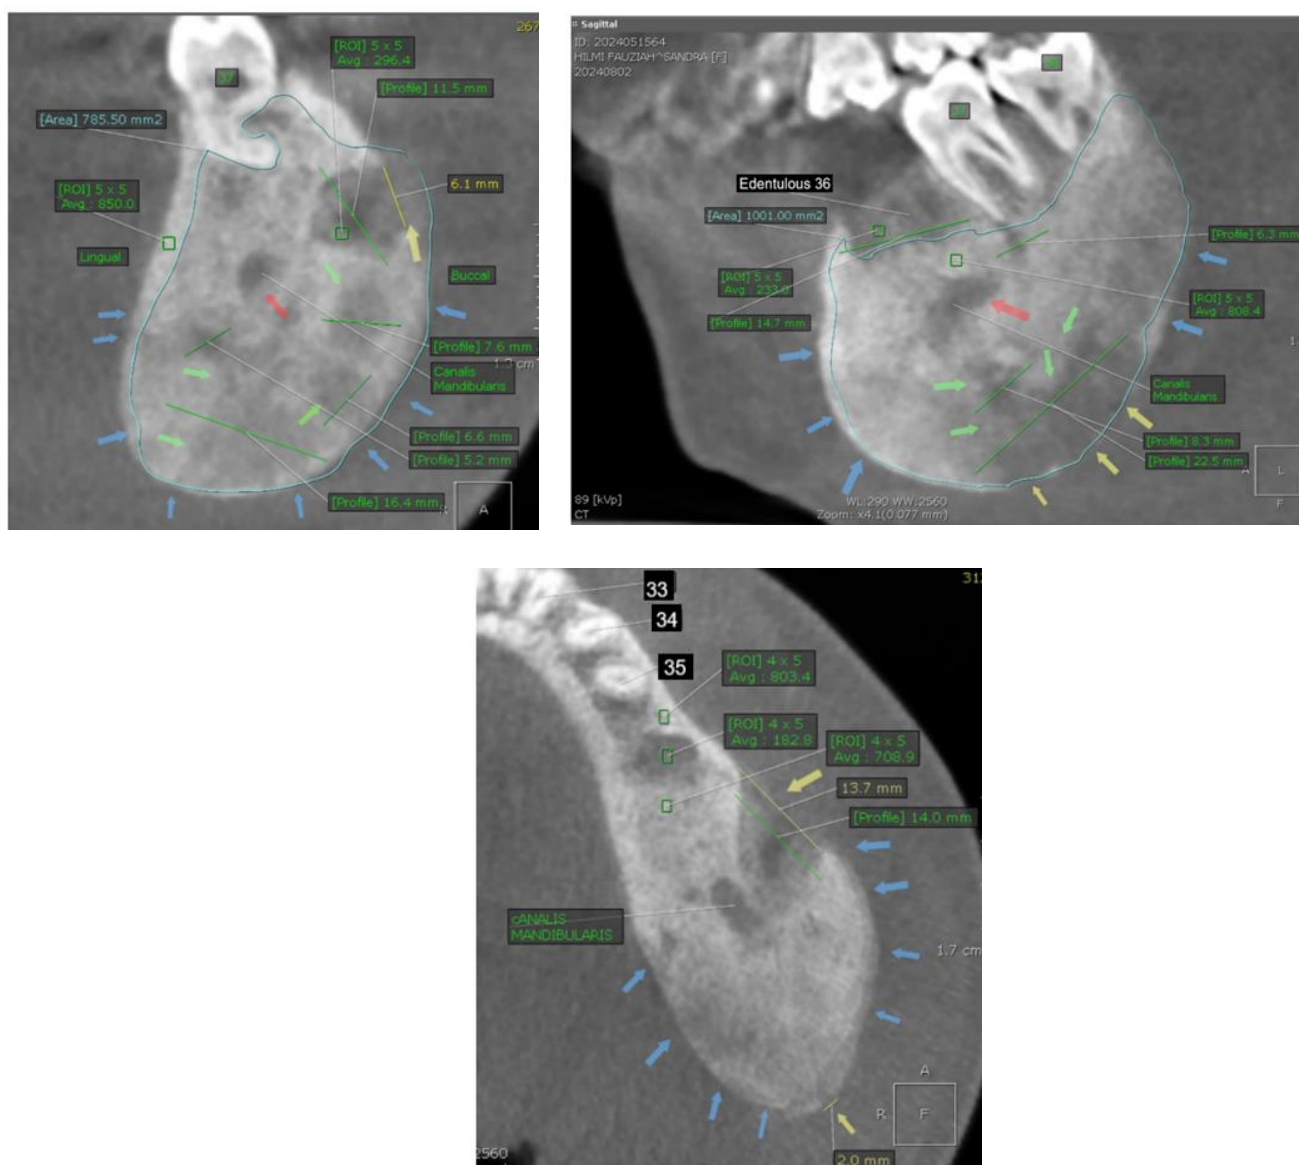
CBCT radiograph, Lesion seen from (A) Axial and (B) Coronal View
